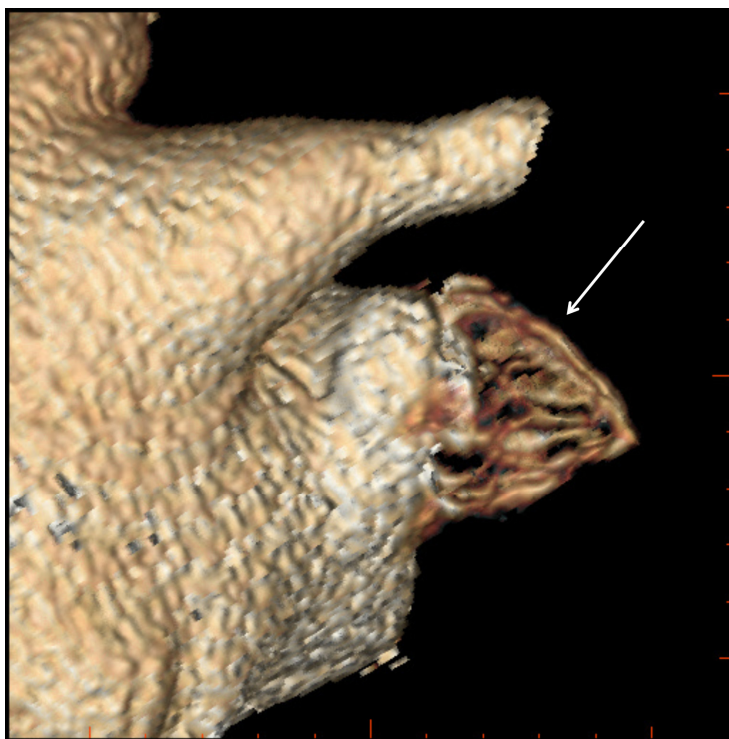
CT detail of the WATCHMAN® device correctly positioned in the left atrial appendage.
